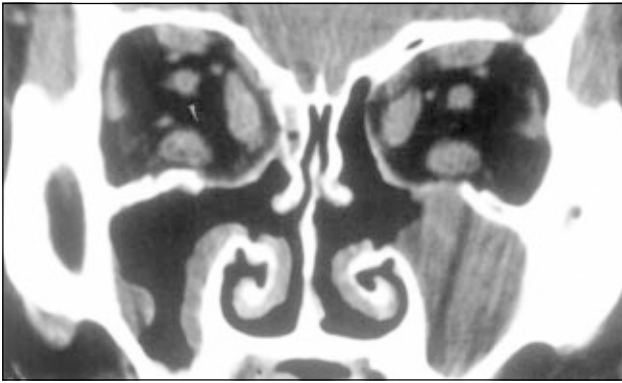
Postoperative coronal computed tomography scan of a patient
